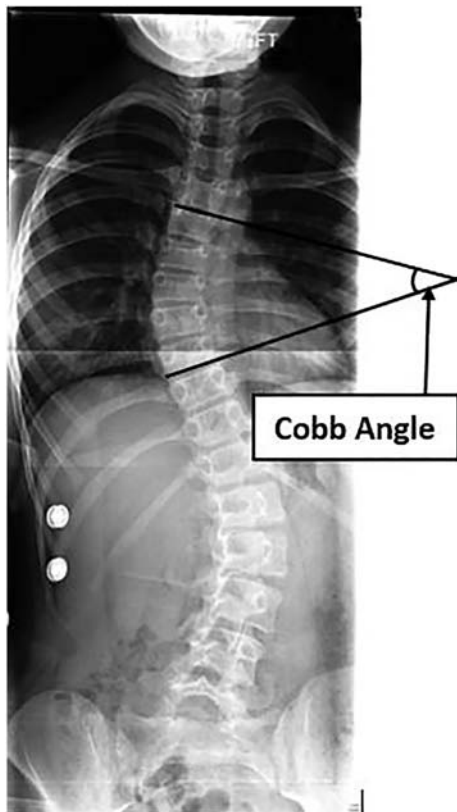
Representation of a Cobb angle. Note how the lines extend beyond the work surface (hard film or computer monitor). This figure was retrieved from the Open-i service of the National Library of Medicine at https://openi.nlm.nih.gov/detailedresult.php?img=PMC2527554_1748-7161-3-11-1&query=scoliosis+x-ray&req=4&npos=706 (last accessed July 14, 2017). License type Attribution 2.0.
